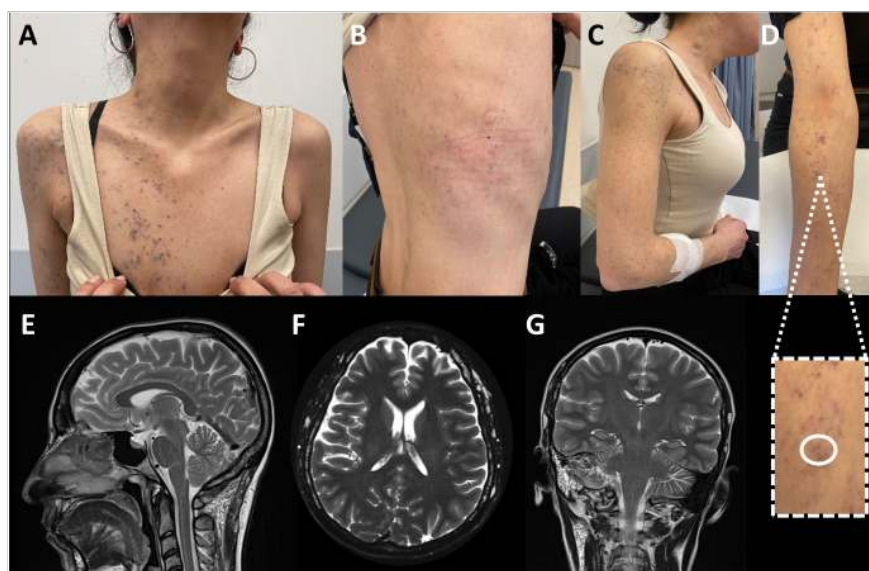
Clinical images of the index 9 showing (A-C) varicose/hemangiomatous lesions limited to the right upper arm and right half of the trunk. (D) Close-up to the right inner arm shows the location of the skin biopsy. (E-G) Cranial MRI showing plexiform neurofibroma on the right internal acoustic canal and multiple meningiomas.
